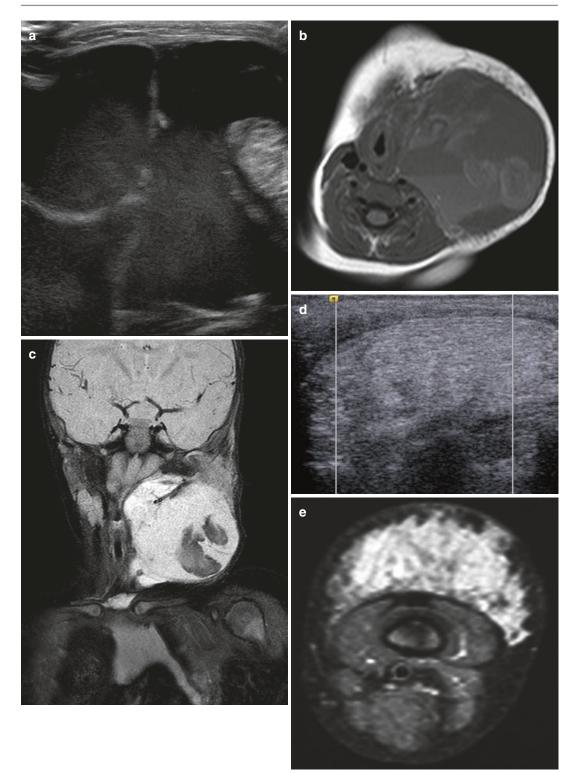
Lymphatic malformations. Macrocystic lesion $(\mathbf{a-c})$ demonstrates large avascular cystic spaces on ultrasound, with fluid-fluid levels and internal debris noted on the axial T1 and coronal T2 weighted MR images.
